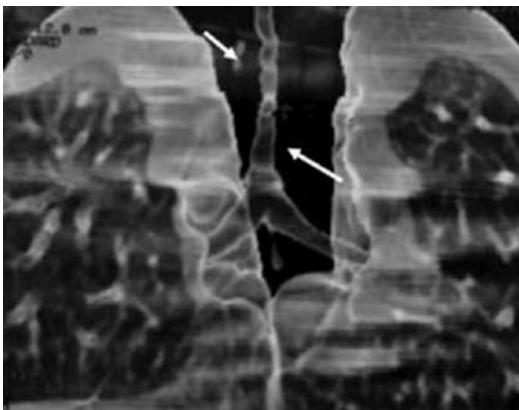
Congenital tracheal stenosis in a 2-month-old patient with a congenital stridor. A multislice CT scan with three-dimensional reconstruction of the airway shows a long segment of tracheal stenosis (*arrows*)
